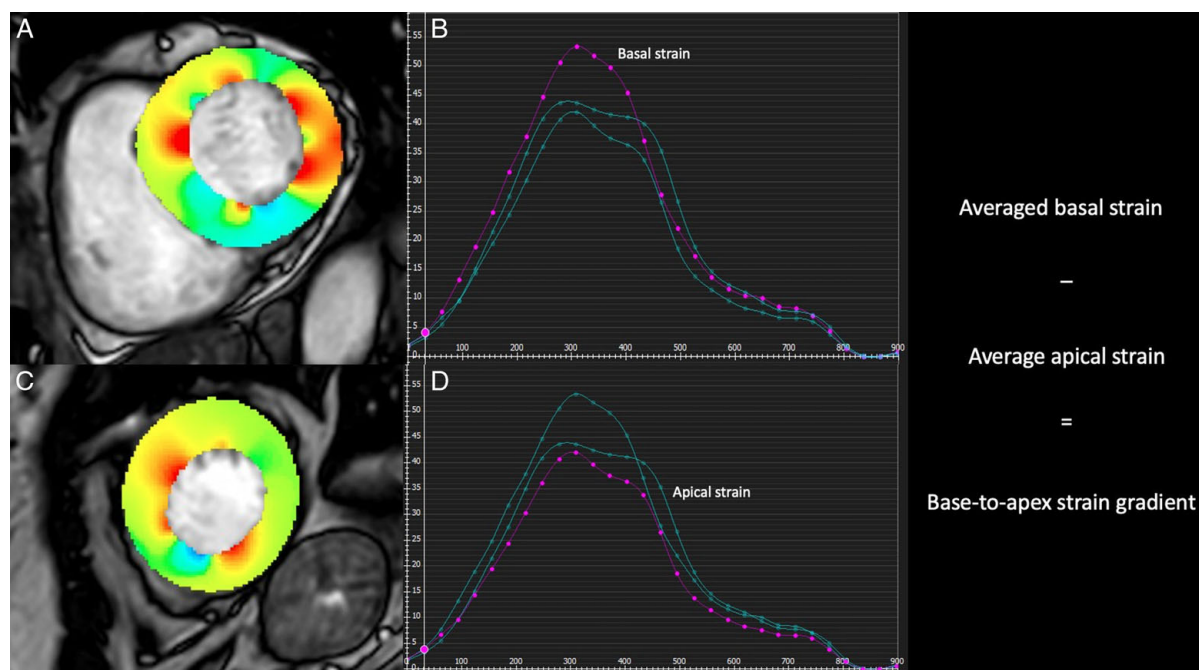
Cardiovascular magnetic resonance images of a 67-year-old male with Takotsubo cardiomyopathy. Basal short-axis cine bSSFP image with color myocardial radial strain map (A) and basal radial strain curve (B, purple curve). Apical short-axis cine bSSFP image with color myocardial radial strain map (C) and apical radial strain curve (D, purple curve). Base-to-apex radial strain gradients were calculated as the peak gradient difference between averaged basal and apical radial strain. The base-to-apex radial strain gradient was 13%. bSSFP indicates balanced steady-state free precession.
